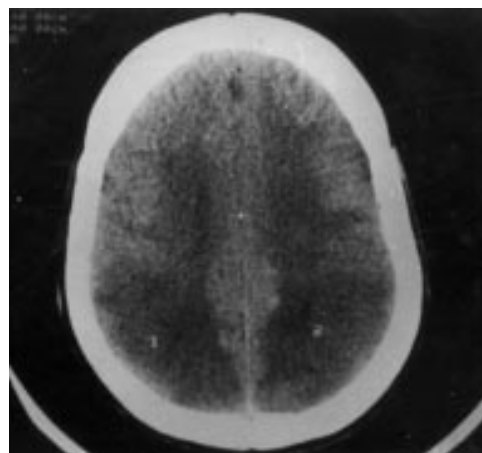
Cranial computed tomography showing bilateral and symmetrical hypodensities involving white and grey matter of posterior parietal and occipital regions of brain. Hypodensity extends well beyond the territory supplied by posterior cerebral arteries.
